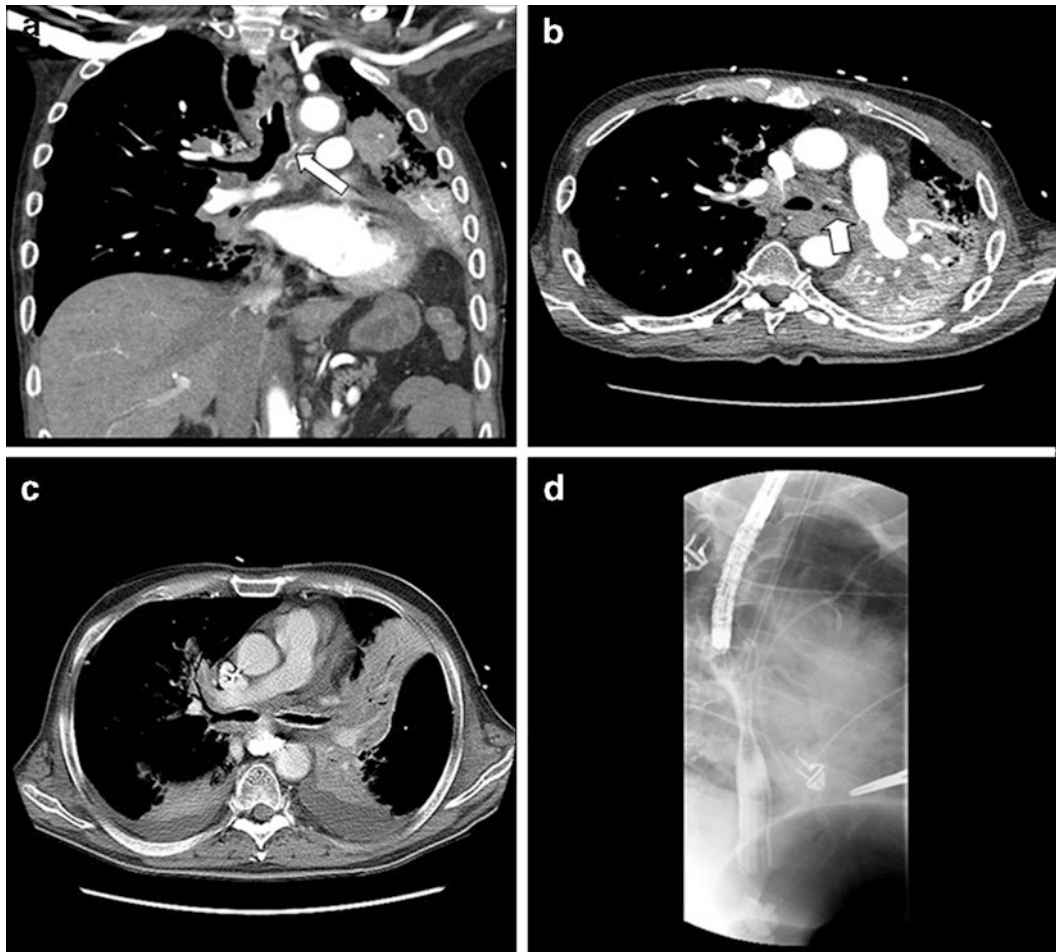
Chest CT scan demonstrating left main stem bronchus (*arrows*) and proximal esophageal obstruction secondary to a squamous cell carcinoma of the lung (a) and (b). A bronchial stent was placed (c)
